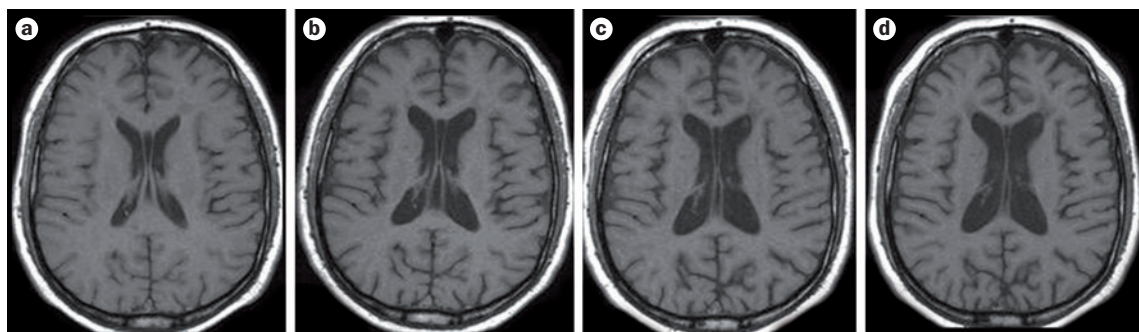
Serial T1-weighted MRI scans in a patient with multiple sclerosis. a | Baseline scan. b–d | Regular scans over a 6-year follow-up period. Disease progression can be seen in the form of the increasing size of ventricular and subarachnoid spaces. These changes reflect brain volume loss over time, indicating progressive neurodegeneration.
